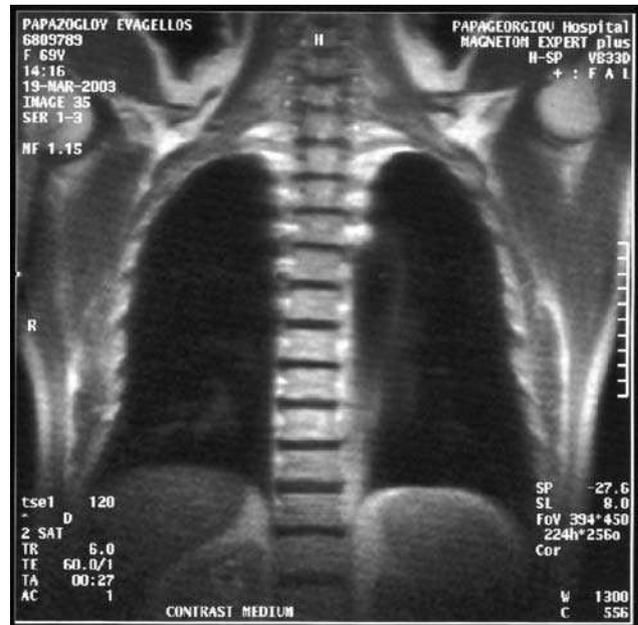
Chest MRI negative of any lesion and lymph nodes
